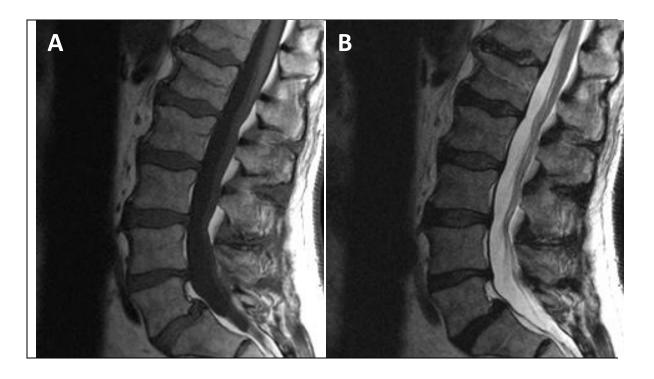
Mid-sagittal MRI sequence of lumbar spine shown with A) T1-weighting and B) T2-weighting. Hyperintensity indicates fat on T1-weighted image and water on T2-weighted image.
